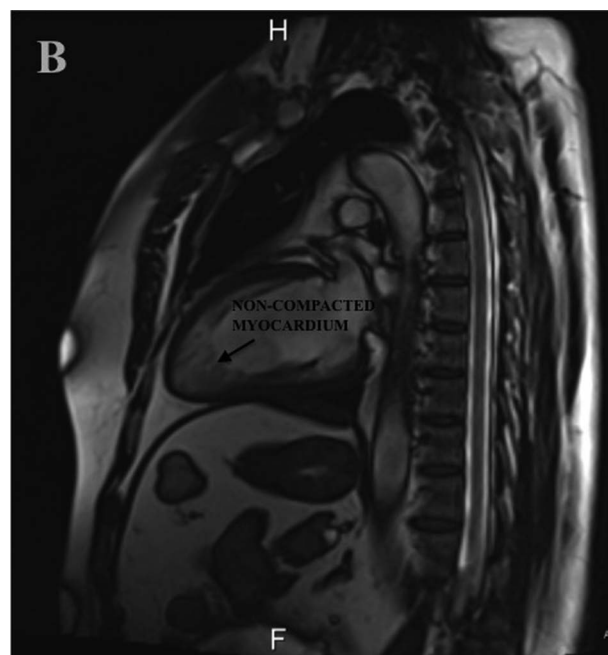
Cardiac MRI showing left ventricular myocardium with significant trabeculations which are extending along the entire cavity of the left ventricle including the apex. The ratio of the non-compacted to compacted myocardium is $>20\%$ suggesting left ventricular non-compaction.
